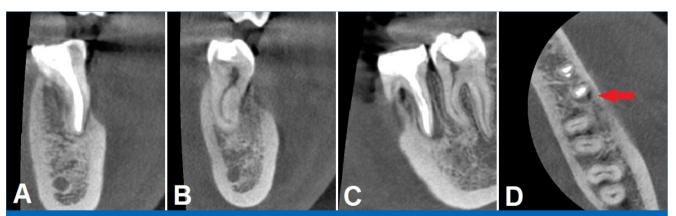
CBCT exam of tooth 36 one year after concluding the treatment. A) coronal view of the mesial root; B) coronal view of the distal root; C) sagittal view; D) axial view, the red arrows mark the remaining periapical lesion.
